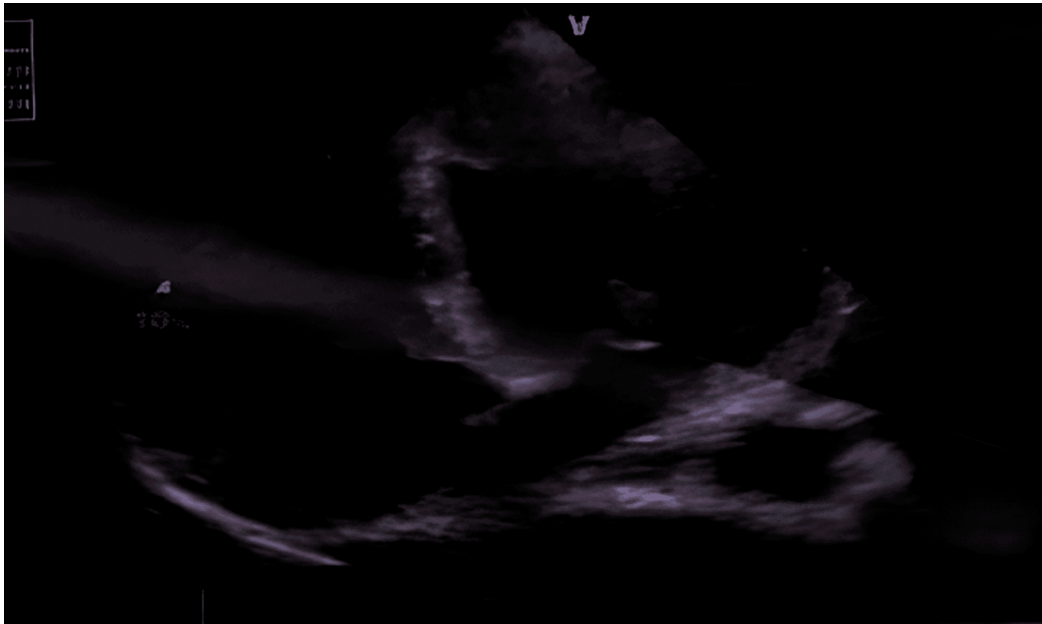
Apical four-chamber transthoracic echocardiography (TTE) showing a vegetation attached to the mitral valve
